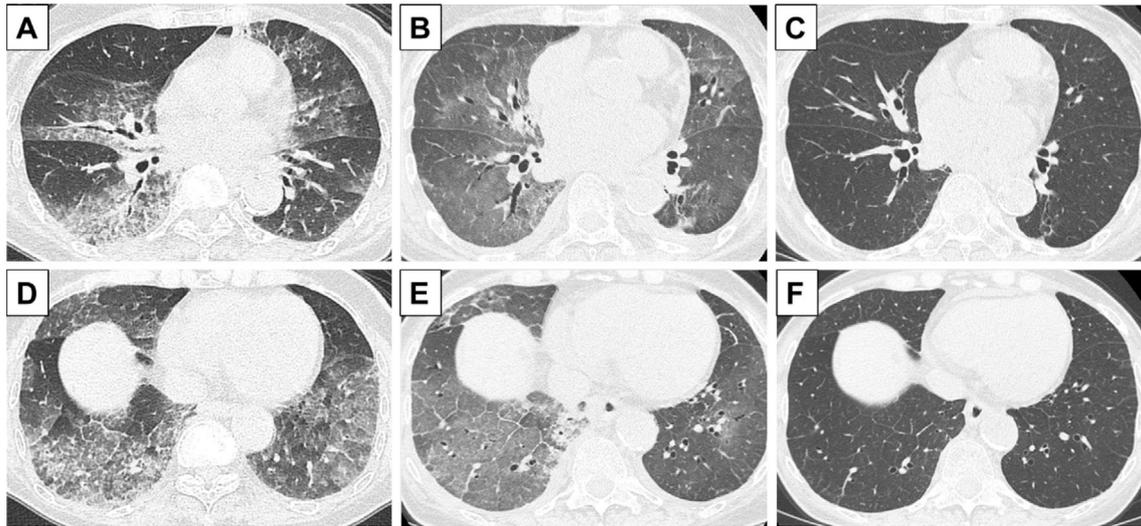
Chest computed tomography two years ago (A, D), on admission (B, E) and eight months after initiation of MM treatment (C, F). GGO, reticulation and interlobular septal thickening were seen predominantly in the bilateral lower lung zones (A, D), with similar features but decreased reticulation (B, E). These findings remarkably improved after MM treatment (C, F). GGO: ground-glass opacity, MM: multiple myeloma
